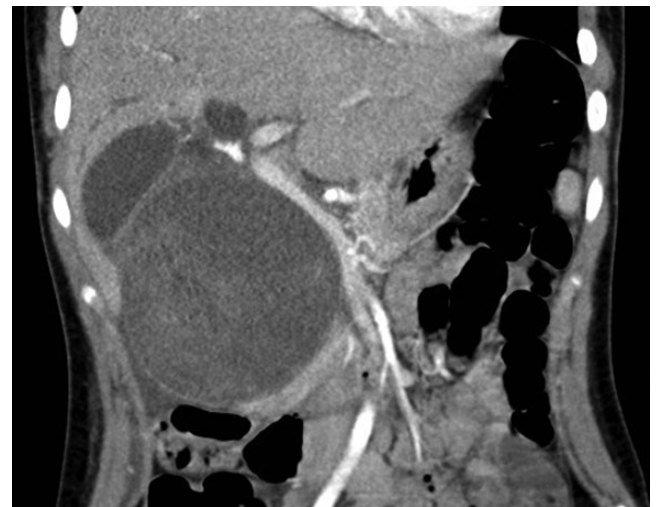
Contrast CT (coronal section) showing a solid pseudopapillary tumor lesion in the head of the pancreas.
